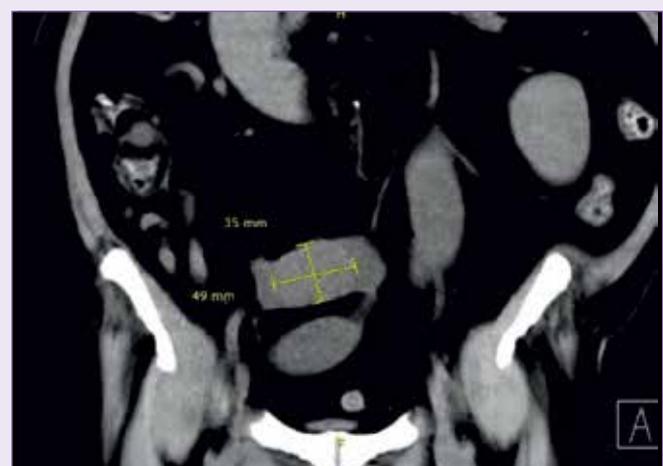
Coronal section of unenhanced CT. The gallstone is better visualised after the narrowing the window settings and its size can be measured.
